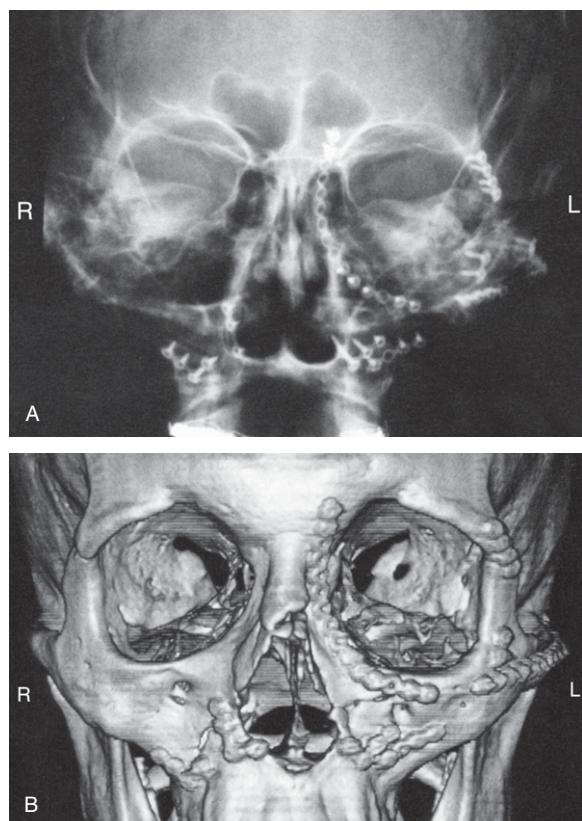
(A (X-ray) and B (CT reconstruction)) Note the internal fixation with a plate and screws in relation to the left zygomaticofrontal synostosis, floor and medial wall of left orbit, left zygomatic arch, floor and medial walls of both maxillary antra.
